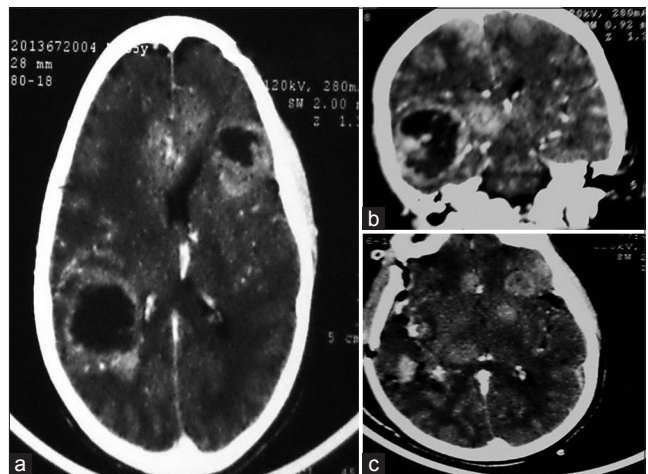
(a and b) Glioblastoma involving multiple supratentorial regions in axial and coronal contrast-enhanced computed tomography, (c) the lesion which was victim for midline shift only targeted for decompression and biopsy
